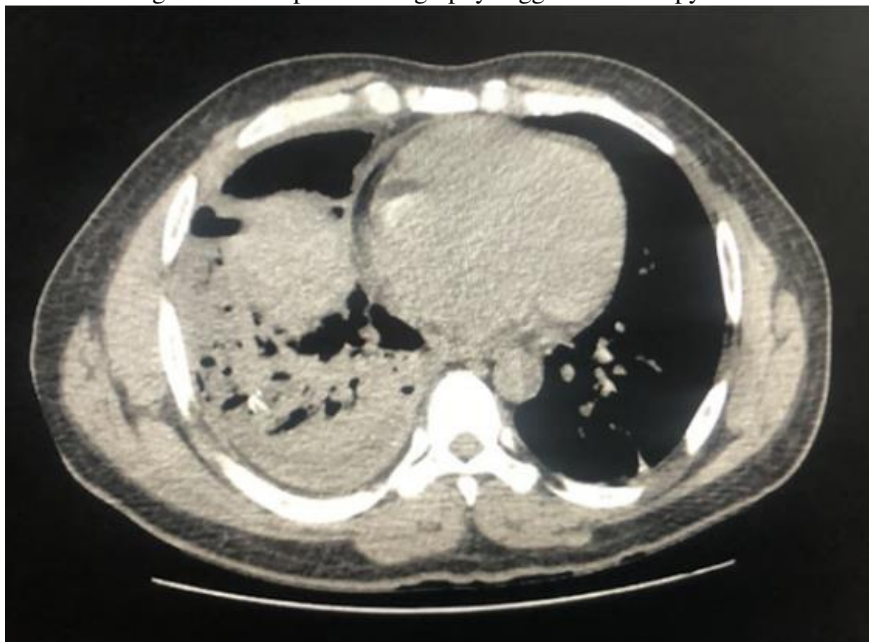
Computed tomography showing worsening of hydropneumothorax and pulmonary contusion.
